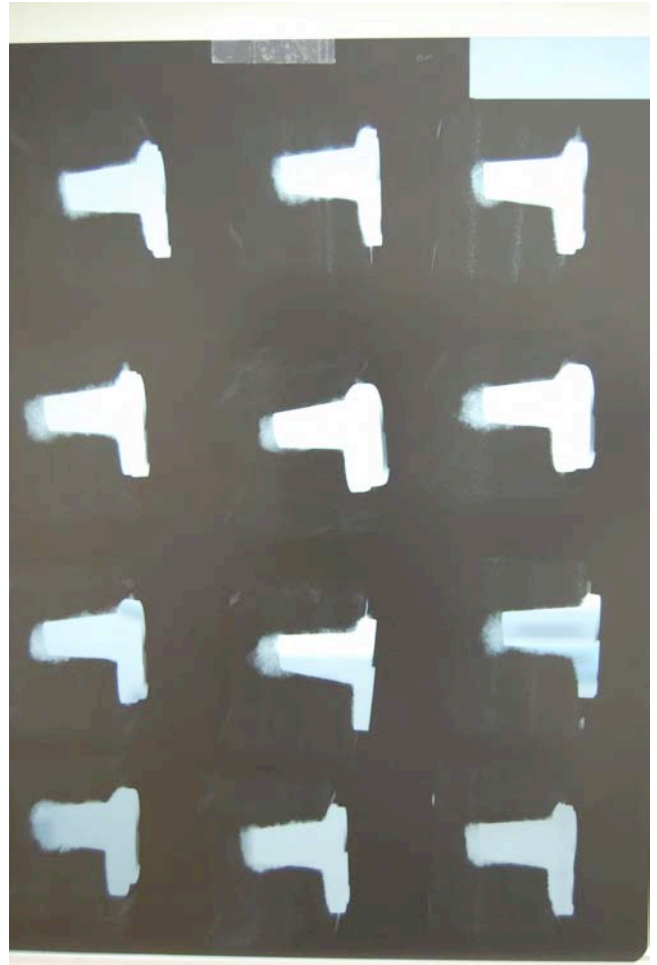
Radiographic analysis: AP view of the cement mantle
